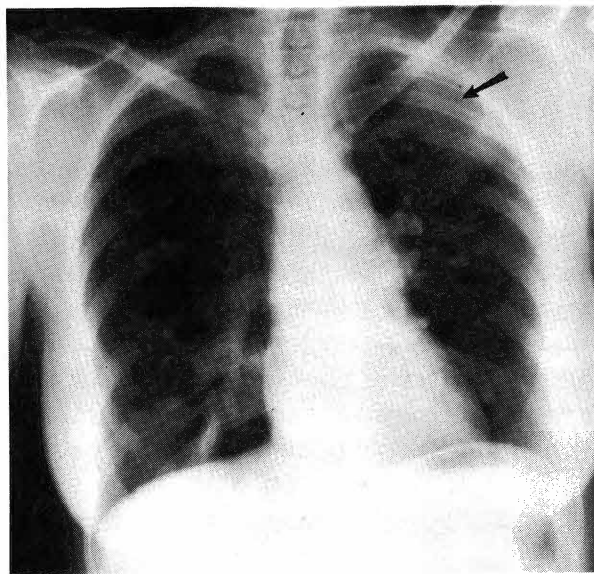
Posteroanterior chest roentgenogram of case 2 showing ill-defined "ground-glass" infiltrate (arrow) in left upper lung field.
